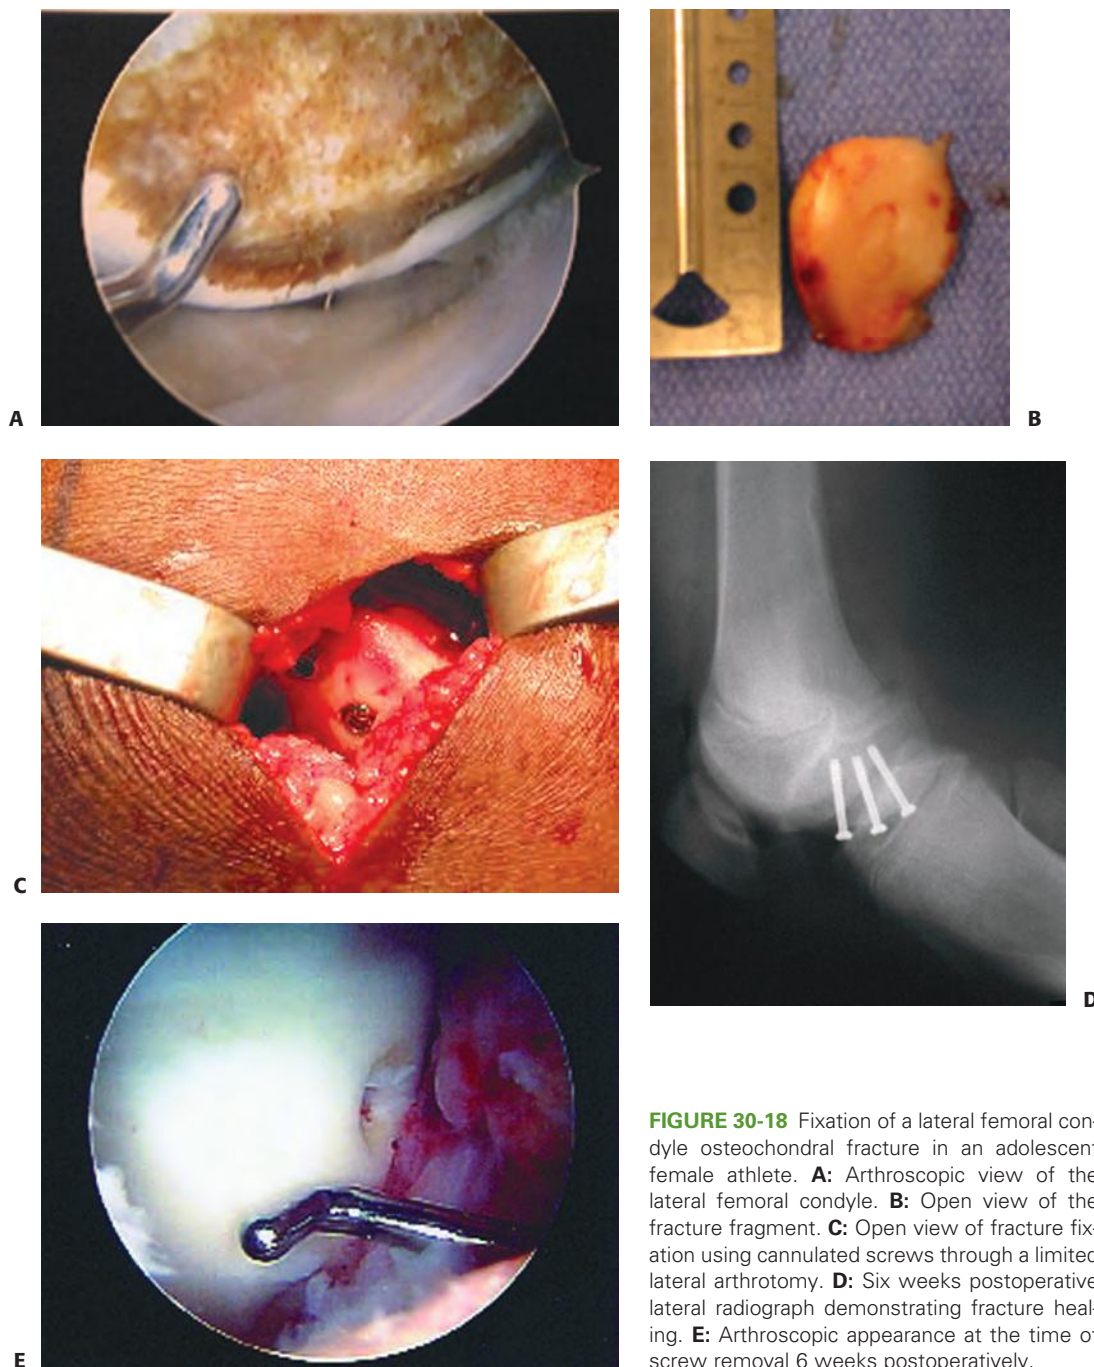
Fixation of a lateral femoral condyle osteochondral fracture in an adolescent female athlete. A: Arthroscopic view of the lateral femoral condyle. B: Open view of the fracture fragment. C: Open view of fracture fixation using cannulated screws through a limited lateral arthrotomy. D: Six weeks postoperative lateral radiograph demonstrating fracture healing. E: Arthroscopic appearance at the time of screw removal 6 weeks postoperatively.
